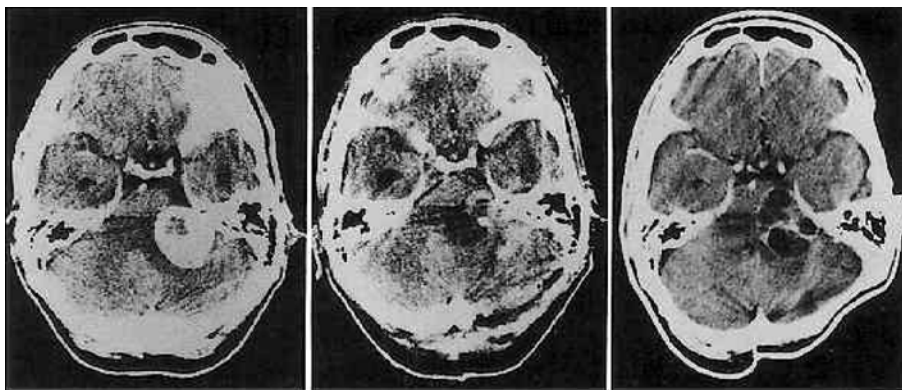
Case 10. Contrast-enhanced computerized tomography (CT) scans in a 72-year-old mechanic with a large left-sided acoustic neurinoma. *Left:* Preoperative CT scan. *Center:* CT scan 1 week postoperatively showing intracapsular removal and collapse of residual capsule. *Right:* CT scan 22 months later showing striking cyst formation around a small residual fragment of tumor.
